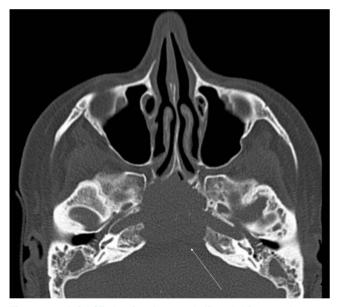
Axial CT showing destroyed clivus (white arrow) secondary to NPC.
